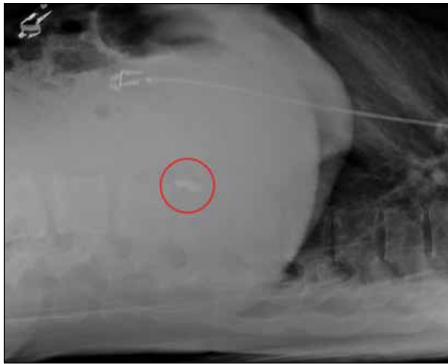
X-ray of bullet near spine, Cimino-Fiallos N (2017), *Gunshot Wounds: A Targeted Approach*.
